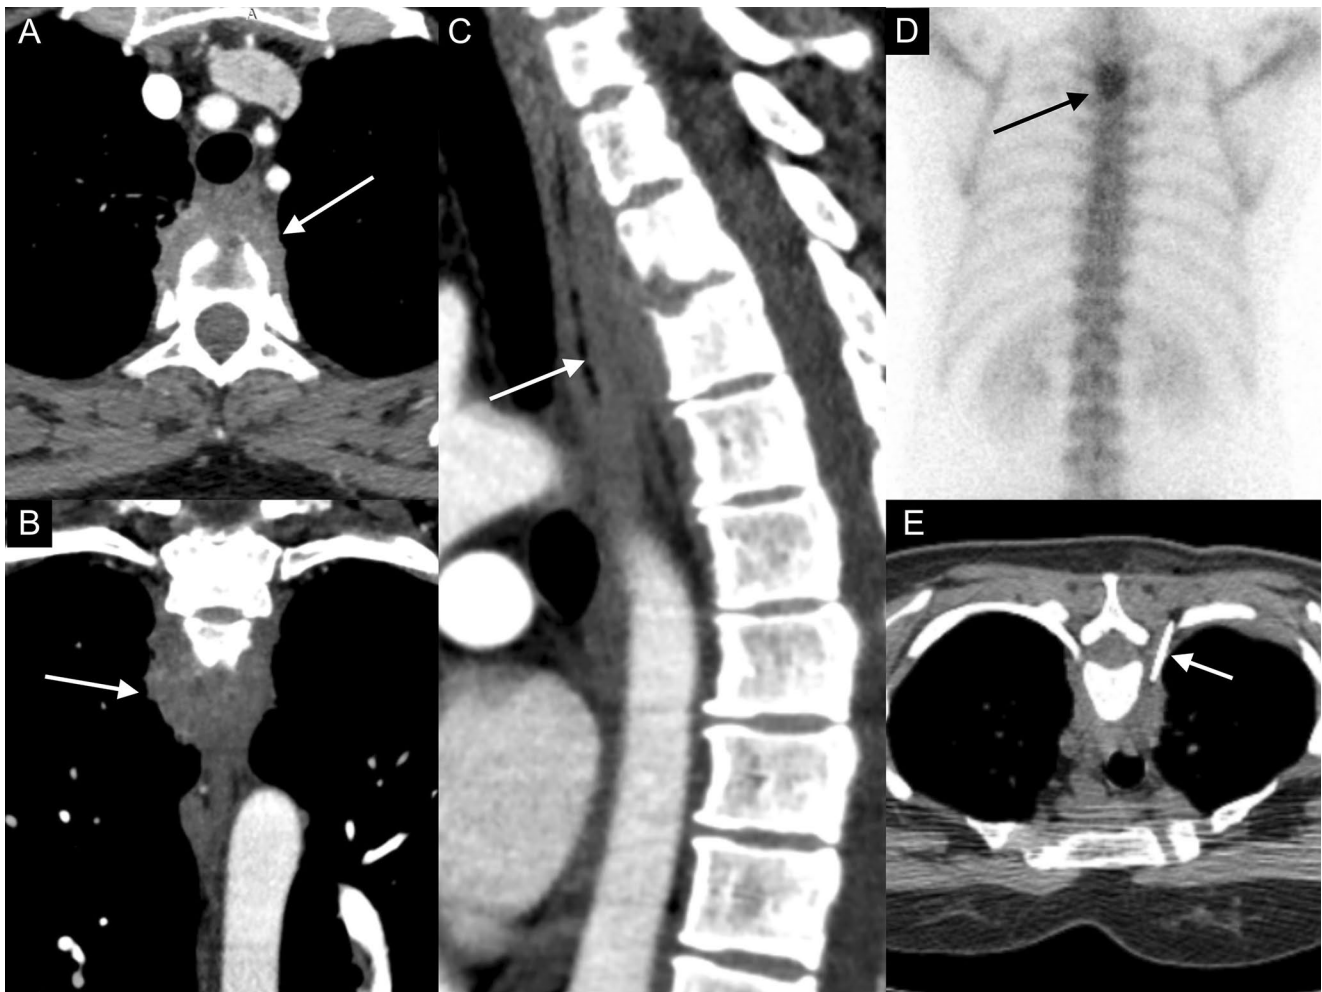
A–C: Initial contrast-enhanced CT on axial, coronal and sagittal, respectively, demonstrating an infiltrating and destructive prevertebral heterogeneous mass (arrows). D: Scintigraphy shows hypercaptation
